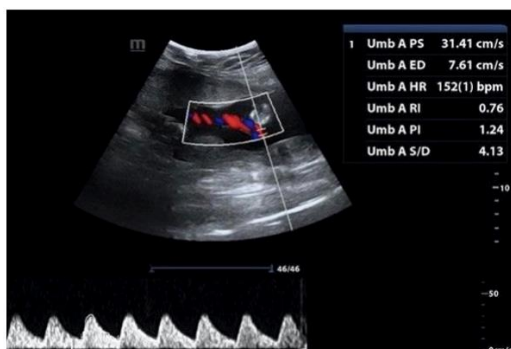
Normal Umbilical Artery Doppler Indices At 22 Weeks
